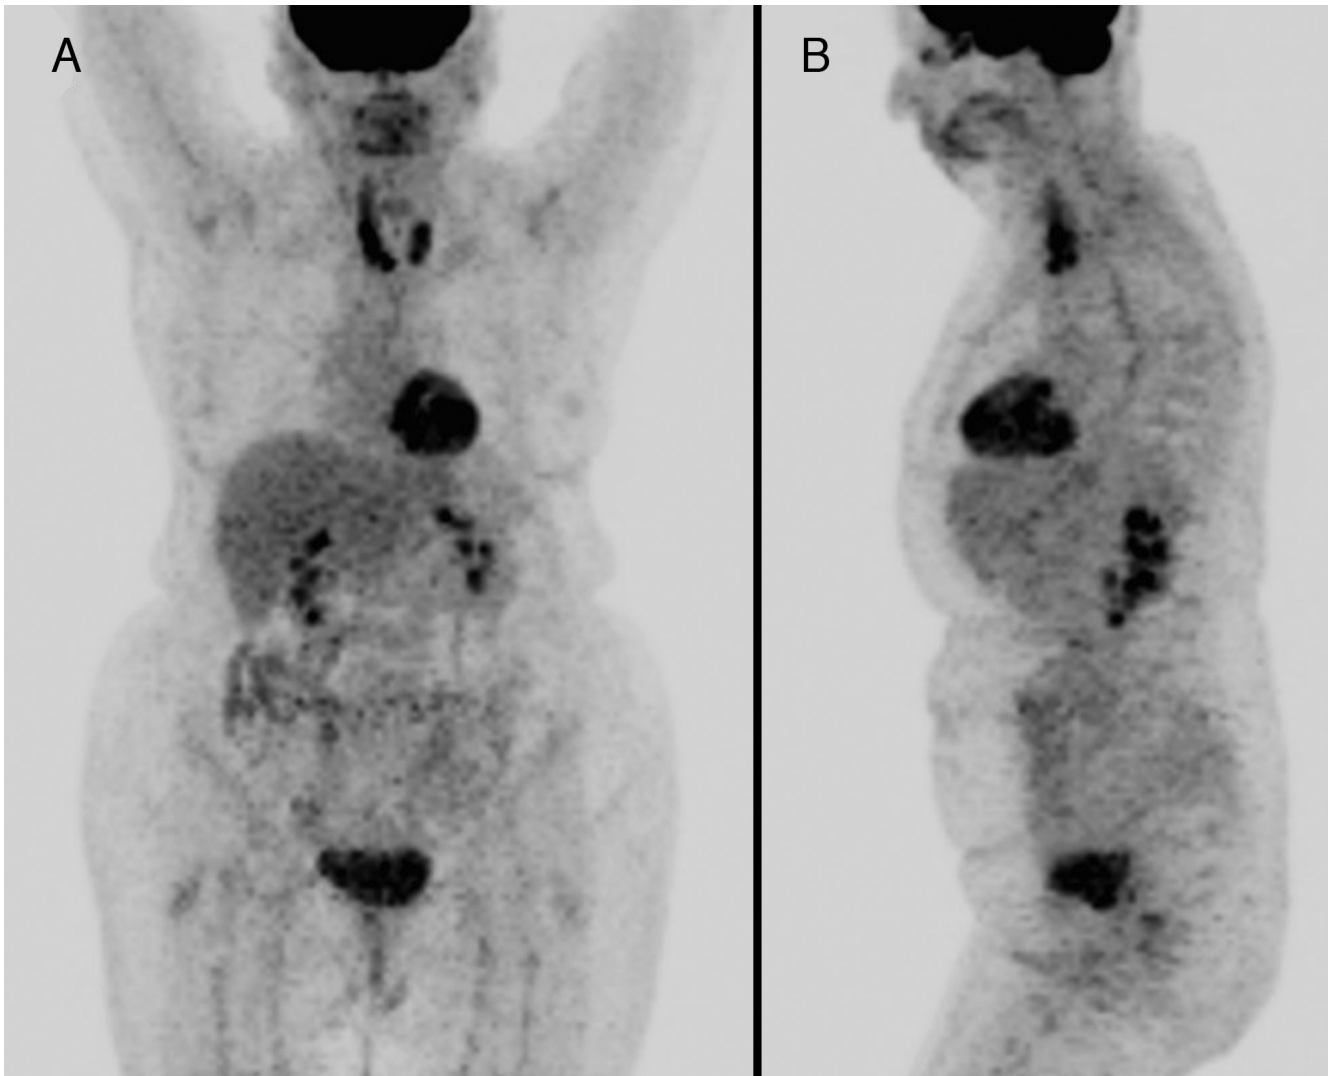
The patient was treated with 3 cycles of CHOP chemotherapy (cyclophosphamide, doxorubicin, vincristine, prednisone) followed by external beam radiation therapy. The first follow-up PET/CT was performed 3 months after the end of radiation therapy and MIP views, (A) anterior and (B) left lateral, show a dramatic reduction in the size of right thyroid DLBCL and resolution of tracheal compression with persistently intense ^{18}F -FDG uptake in both thyroid lobes with SUV_{max} 8.9 on the right. These findings were interpreted as partial response to therapy, however since the patient was asymptomatic, a conservative management approach was taken.
